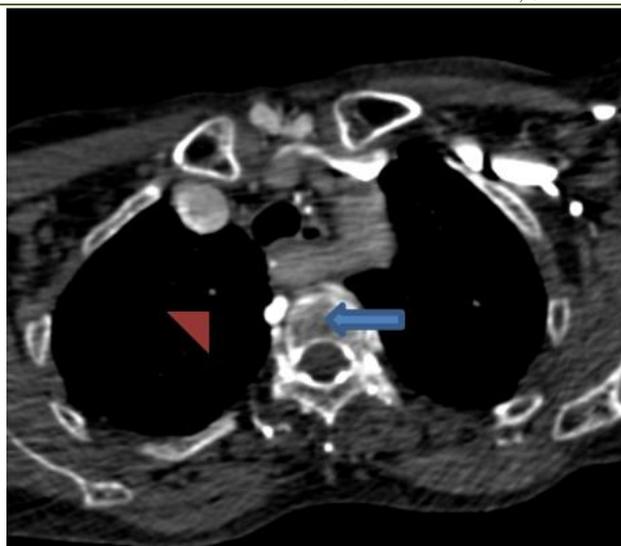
Postcontrast Computed Tomography – Angiography axial image Truncus bicaroticus gives rise to the right common carotid artery (arrow head) and the left common carotid artery (bleu arrow) associated with arteria lusoria
